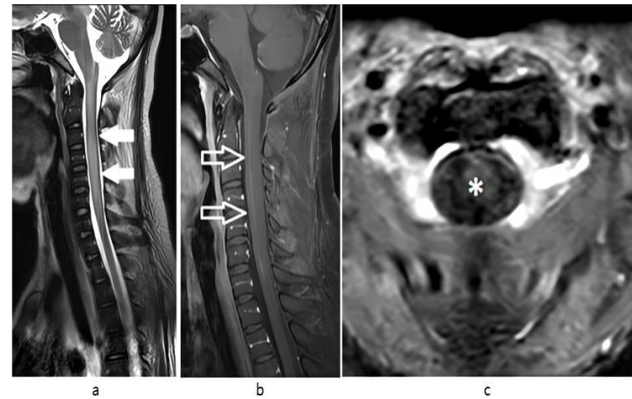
MRI upper cervical spine in sagittal T2 weighted (a), sagittal (b), & axial (c) post contrast sequences shows spine enlargement and hyperintensity at the upper cervical spine region (arrow), which showed enhancement (open arrow, *) post gadolinium (Reprinted with permission of the patient)
